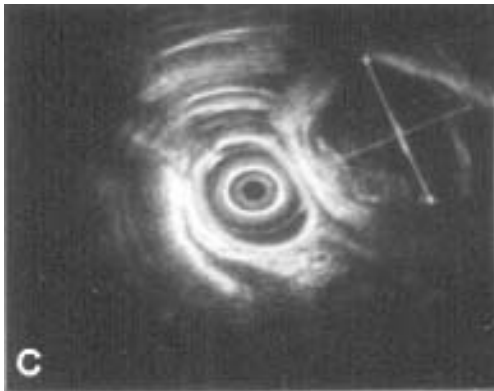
Appearance of the cyst in the endorectal ultrasound scan.
